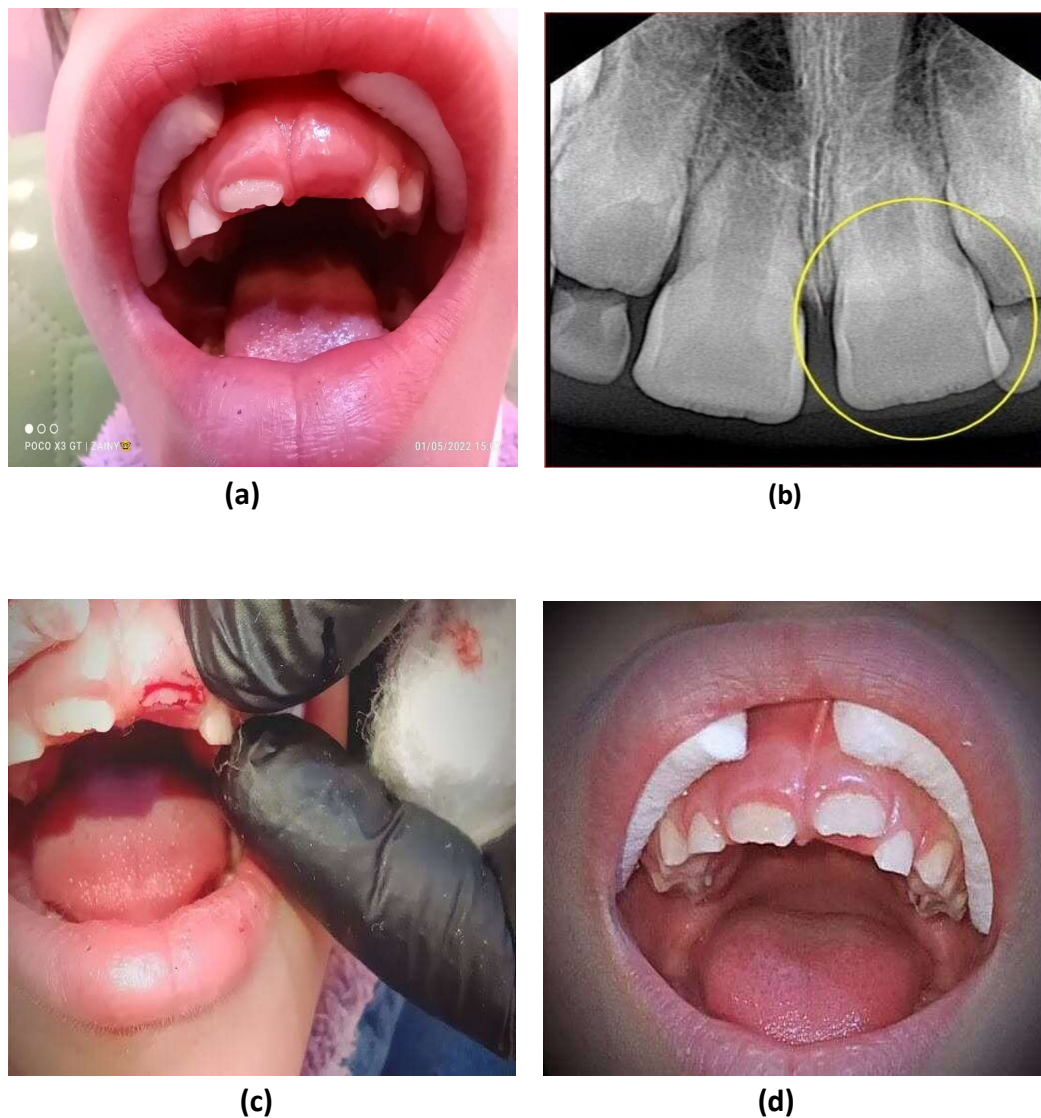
Surgical blade excision technique of gingival fibromatosis in left central incisor region for the 9-year-old female patient: (a) Pre-operative clinical feature, (b) Pre-operative periapical radiograph, (c) Immediately postoperative view and (d) Complete healing and eruption of the affected tooth after four weeks post-operatively.
